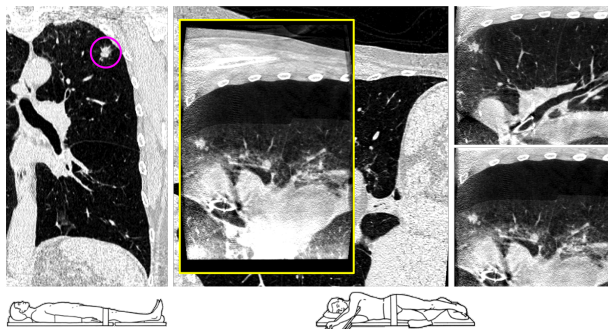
Left: preoperative CT image with the patient in supine position. Right: intraoperative CBCT images of the inflated (CBCT<sub>inf</sub>) and deflated (CBCT<sub>def</sub>) lung with the patient in *lateral decubitus* position. Middle: superposition of the preoperative CT image rigidly registered to the intraoperative CBCT<sub>def</sub> image. The FOV of the CBCT<sub>def</sub> image (outlined in yellow) only provides a partial view of the lung. The nodule is encircled in the preoperative CT image and is visible in all other images.
